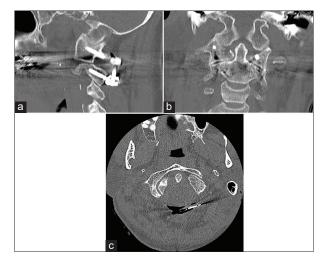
Postoperative CT cervical spine. Sagittal (a), coronal (b), and axial (c) bone window CT cervical spine day 2 after surgery demonstrates the restoration of C1-C2 alignment.
